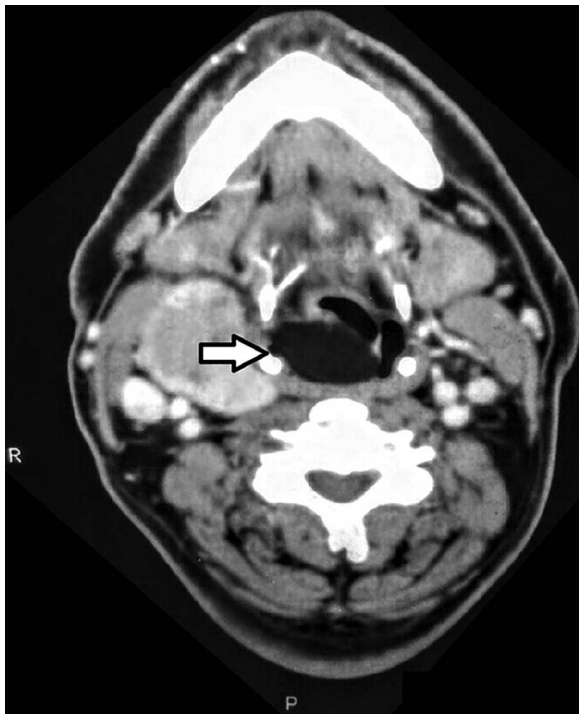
CT scan. Arrow showing lesion in the supraglottis compromising airway. The right lobe of multi-nodular goitre is also seen.
